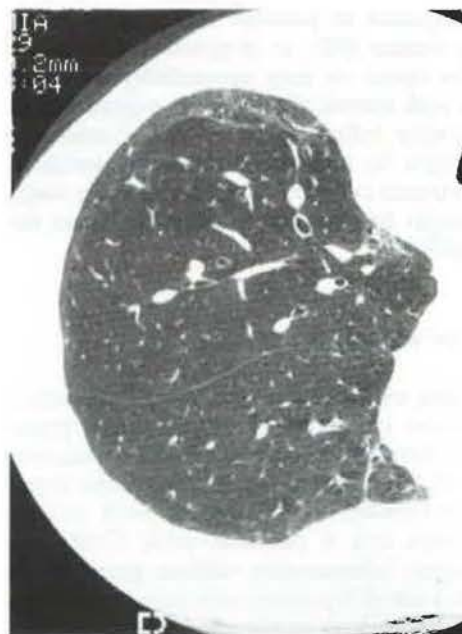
High resolution CT scan in the prone position with window setting appropriate for lung parenchyma in a patient with progressive systemic sclerosis, normal chest roentgenogram and subclinical neutrophil alveolitis. Thickened septal lines and fine honeycombing are shown. CT: computed tomography.
